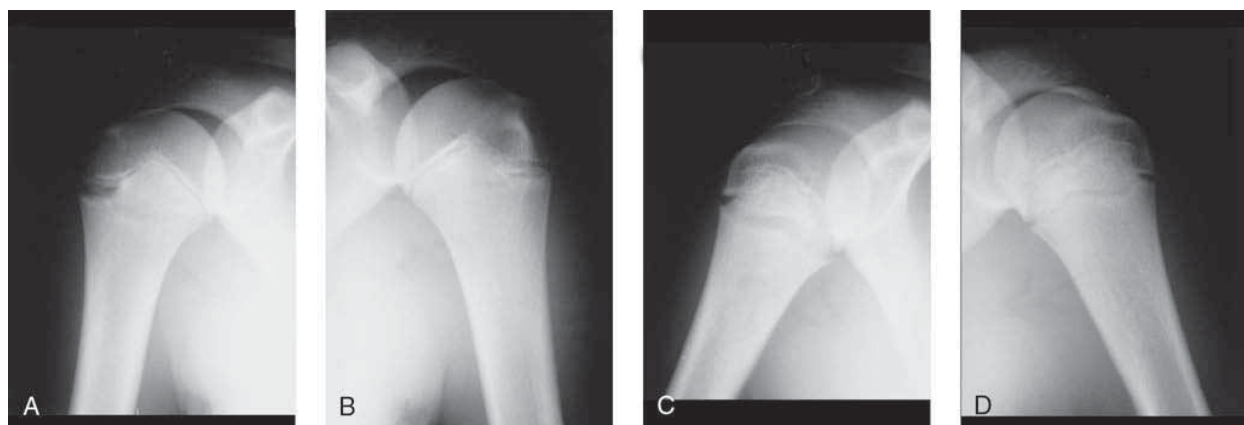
External rotation (A and B) and internal rotation (C and D) comparison radiographs of a skeletally immature patient with Little Leaguer's shoulder. Note the physeal widening in the right throwing shoulder (A and C) compared with the left shoulder (B and D). (Reprinted with permission from Carson WG Jr, Gasser SI: Little Leaguer's shoulder: A report of 23 cases. *Am J Sports Med* 1998;26:577.)
